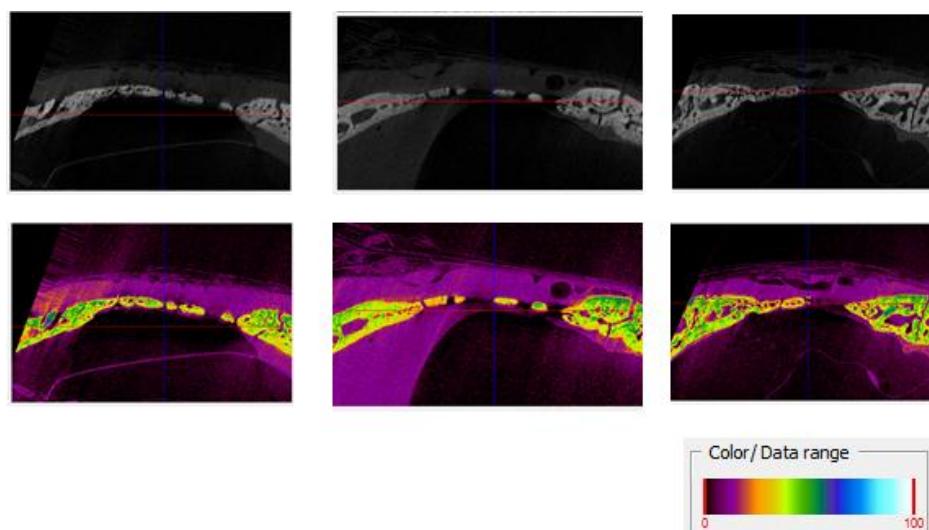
Micro CT images of three control defects at 4 weeks. The upper panel is of raw CT images, the lower panel is a view of the density gradient. Color key on right bottom represents the bone density.
